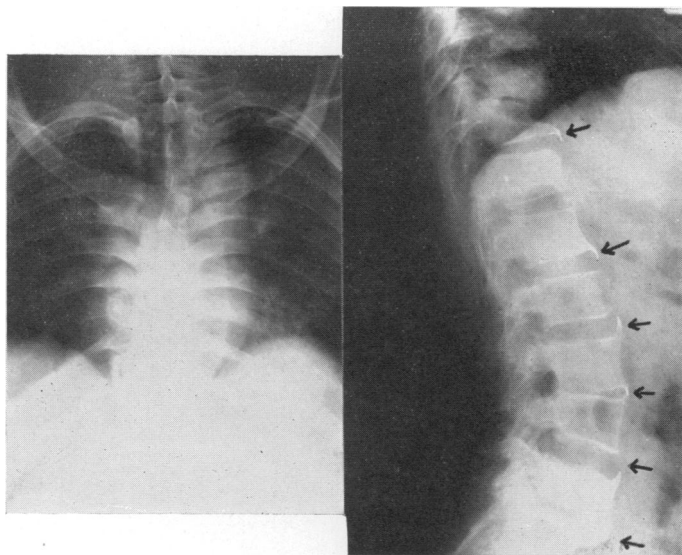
X-rays showing the formation of bridging.
